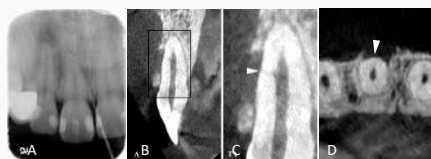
(A) Preoperative periapical radiograph. A lateral lesion of tooth #8 was traced with GP. (B,C) Sagittal plane, CBCT scan of tooth #8. The white arrow points to a lateral canal. (D) Axial plane of middle root, CBCT scan.
